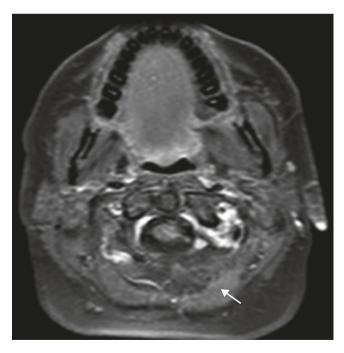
Magnetic resonance imaging revealing atrophy of the left splenius capitius muscle (*white arrow*) after an occipital nerve block
